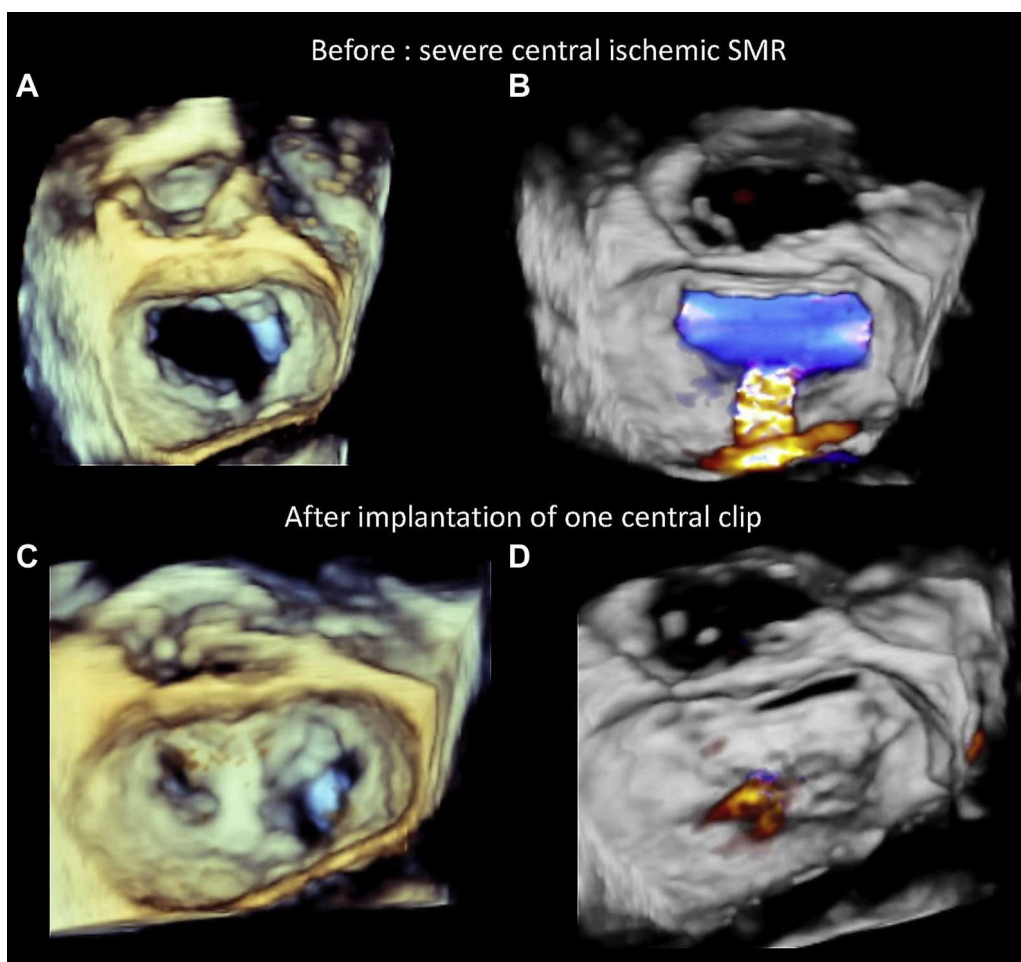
Percutaneous edge-to-edge mitral valve repair of a patient with ischemic secondary mitral regurgitation (SMR) on (A) three-dimensional (3D) transesophageal echocardiography (TEE) and (B) 3D TEE color en-face view showing central SMR. (C) A 3D-TEE en face view after a successful procedure with implantation of 2 central MitraClips (Abbott Vascular, Menlo Park, CA). (D) Transthoracic echocardiographic 3-chamber view shows persistent good results at 1 year with residual mild mitral regurgitation and a gradient at 4 mm Hg.
